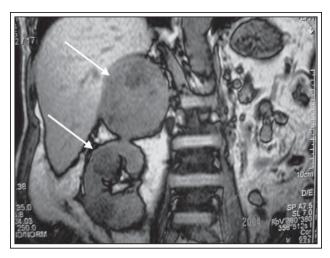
MRI of right adrenal and renal metastases. (19 years after nephrectomy).
